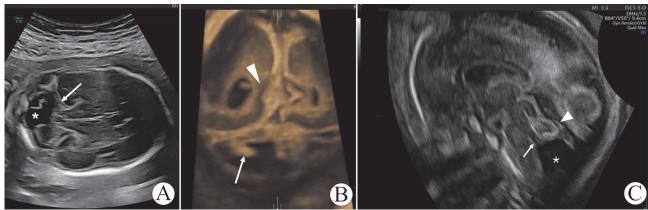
Imaging features of Blake's pouch cyst and associated cerebellar abnormalities. A A two-dimensional ultrasound image of the posterior fossa on the axial plane revealing a communication between the fourth ventricle and the cisterna magna, attributed to a Blake's pouch cyst (indicated by *), accompanied by unilateral cerebellar hypoplasia (highlighted by the arrow). B On the three-dimensional coronal plane, an underdevelopment of the left calcarine sulcus (marked by the arrowhead) and unilateral cerebellar hypoplasia (indicated by the arrow). C A three-dimensional ultrasound image on the midsagittal plane demonstrates partial vermis agenesis and a Blake's pouch cyst (indicated by *), causing upward rotation of the vermis. The fastigium (highlighted by the arrow) and the primary fissure (marked by the arrowhead) are absent.
